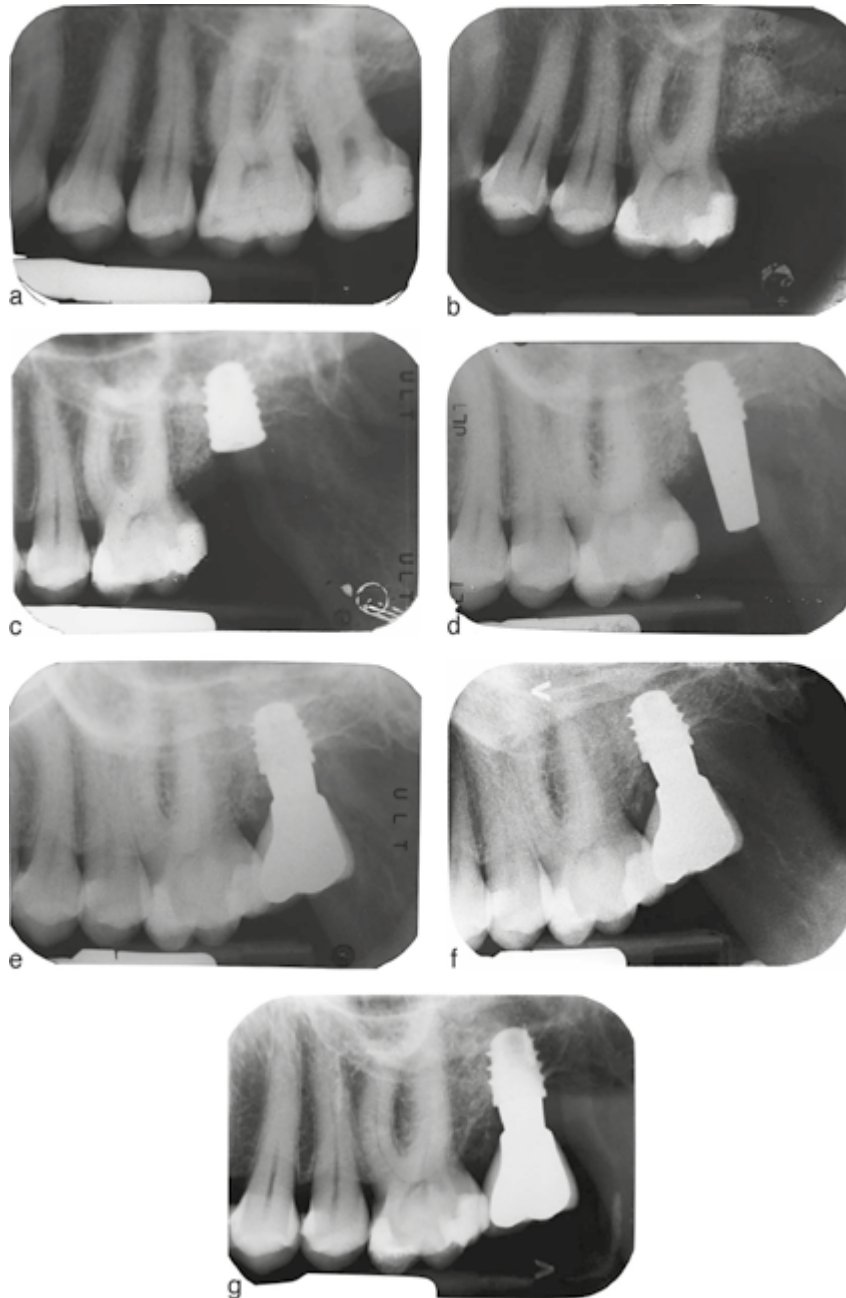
(a) Element #15 has to be extracted for periodontal problems. (b) Preoperative implant site #15. (c) Radiograph after implant surgery. (d) Radiograph after abutment connection. (e) Radiograph at delivery of definitive prosthesis. (f) Radiograph at 3-year follow-up. (g) Radiograph at 4-year follow-up.
